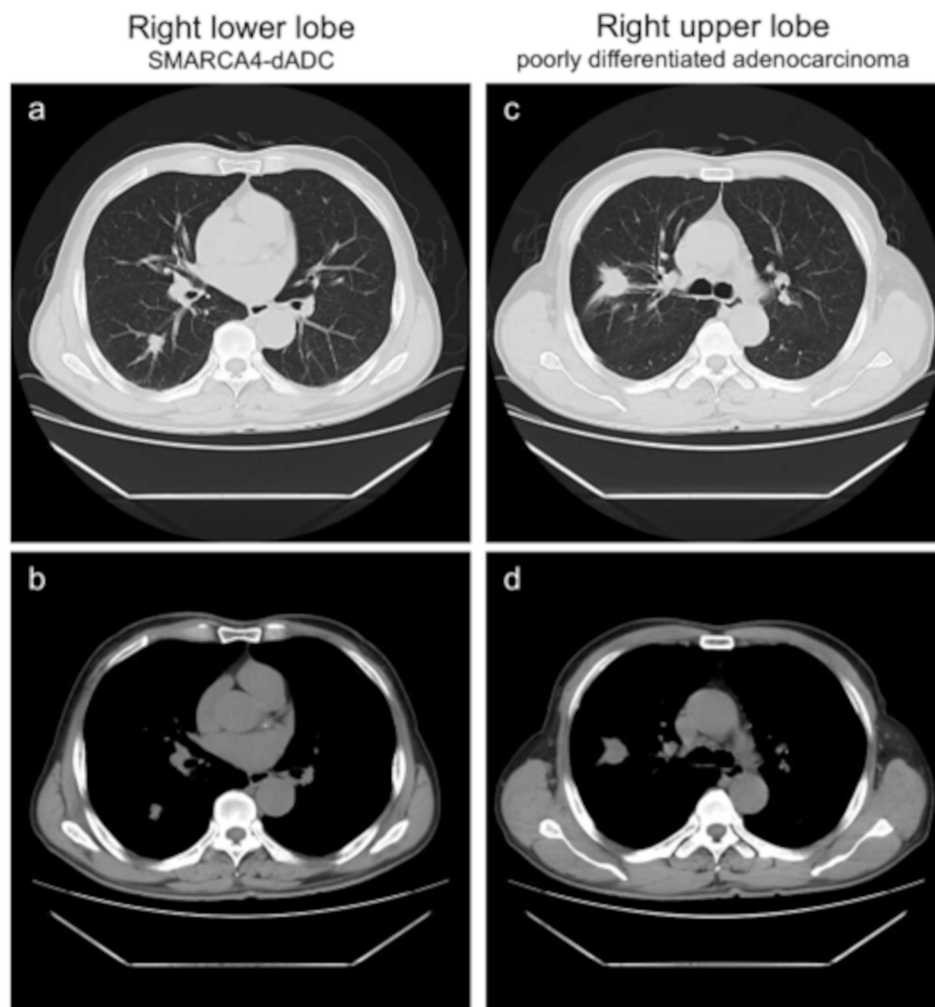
Chest CT images of the patient. (a) CT images of the lung window with a lung mass in the right lower lobe. (b) CT images of the mediastinum window with a lung mass in the right lower lobe. (c) CT images of the lung window with a lung mass in the right upper lobe. (d) CT images of the mediastinum window with a lung mass in the right upper lobe
